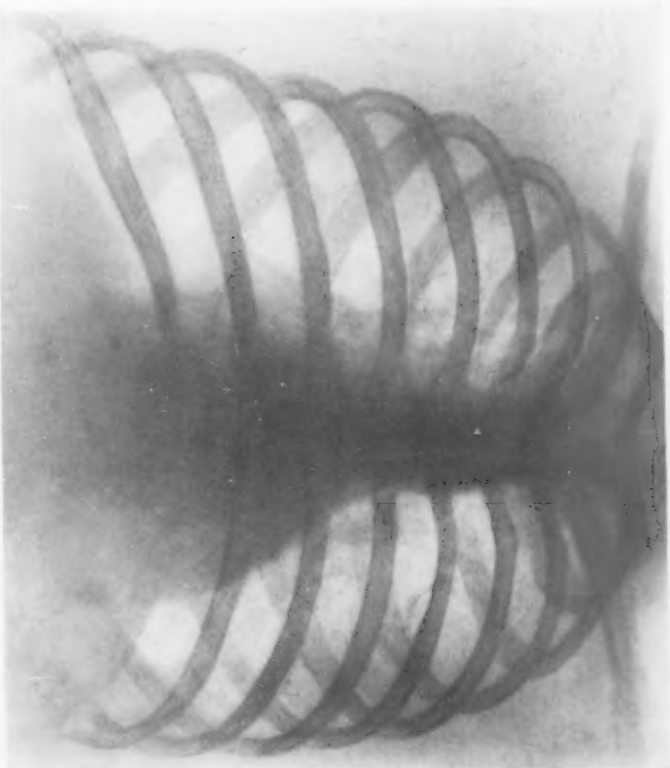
The end-result in the case shown in Fig. 5. (X-ray taken twelve months after beginning treatment.) The cavity is obliterated. The shadow cast by the thickened pleura has practically entirely disappeared.
